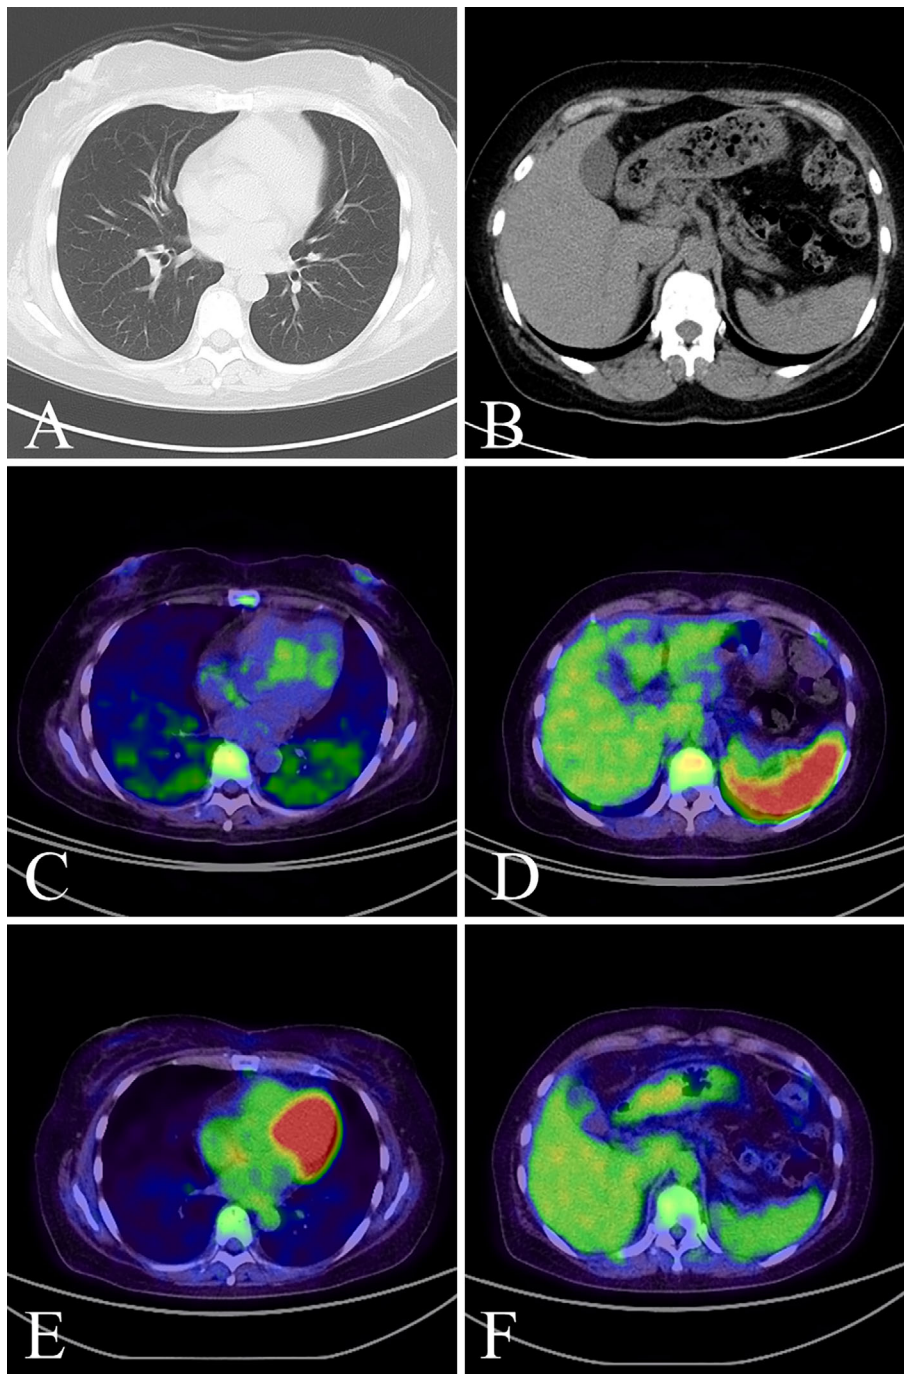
Whole-body computed tomography. No significant findings were detected at the onset of thrombocytopenia (A, B). On the 51st day of treatment, a diffuse increased uptake in the enlarged spleen and slight uptake in the lungs were noted on positron-emission tomography/computed tomography (C, D). The uptake in these lesions decreased after chemotherapy (E, F).
